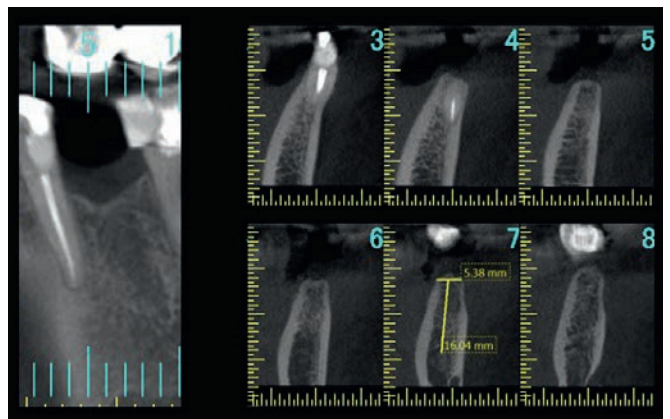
Follow-up CBCT at four months post-extraction. The extraction socket is completely remodeled with new woven bone.
